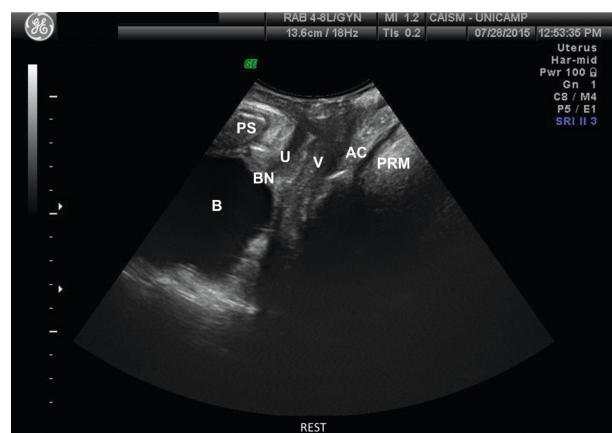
Sequential representation of the structures observed in the pelvic floor muscles' ultrasound image. PS = Pubic symphysis; U = Urethra; BN = Bladder neck; B = Bladder; V = Vagina; AC = Anal canal; PRM = Puborectalis muscle.
